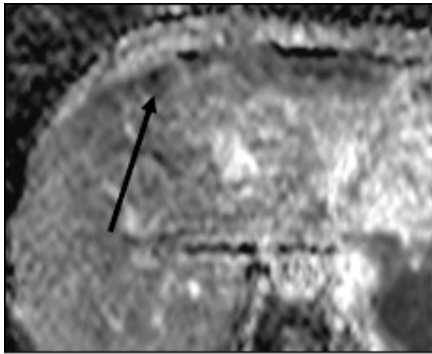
Typical liver metastasis. A. I.v. contrast-enhanced MDCT in the arterial phase showing a slight enhancement in the metastasis. B & C. Transverse T1-weighted (B) and T1-weighted gadolinium contrast-enhanced T1-weighted MRI in the arterial phase (C) showing an hypointense metastasis with rim enhancement. D & E. Transverse DW MRI (b 600), showing a hyperintense metastasis (white arrow), with a very low ADC appearing as a dark area (black arrow).
